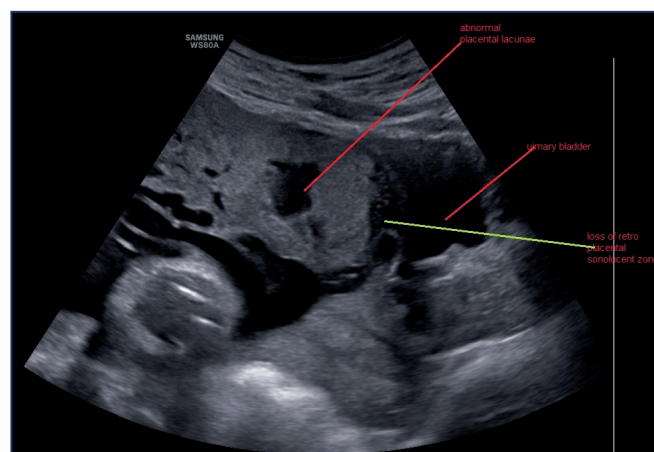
2D gray-scale ultrasound showing loss of retro-placental sonolucent zone and abnormal placental lacunae.
